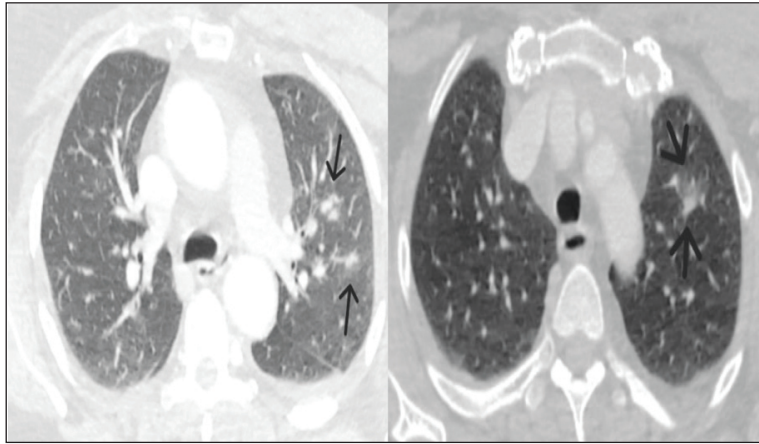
Nodular lesions seen on lung CT.
